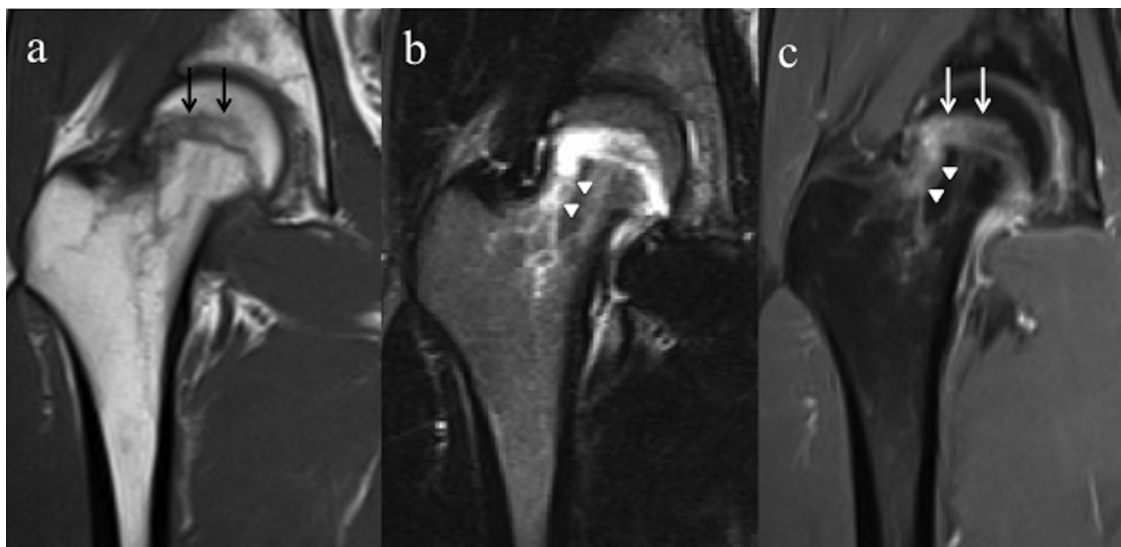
a–c Magnetic resonance images (MRI) performed 4 months after the injury following the onset of right hip pain. (a) A coronal T1-weighted image shows a low-intensity band convex to the articular surface above the epiphyseal scar (black arrows). (b) A coronal short-tau inversion recovery (STIR) sequence image shows bone marrow edema changes around the band (white arrowheads). (c) On gadolinium-enhanced magnetic resonance image MRI, the band and surrounding area were enhanced (white arrows), accompanied by diffuse bone marrow edema (white arrowheads).
